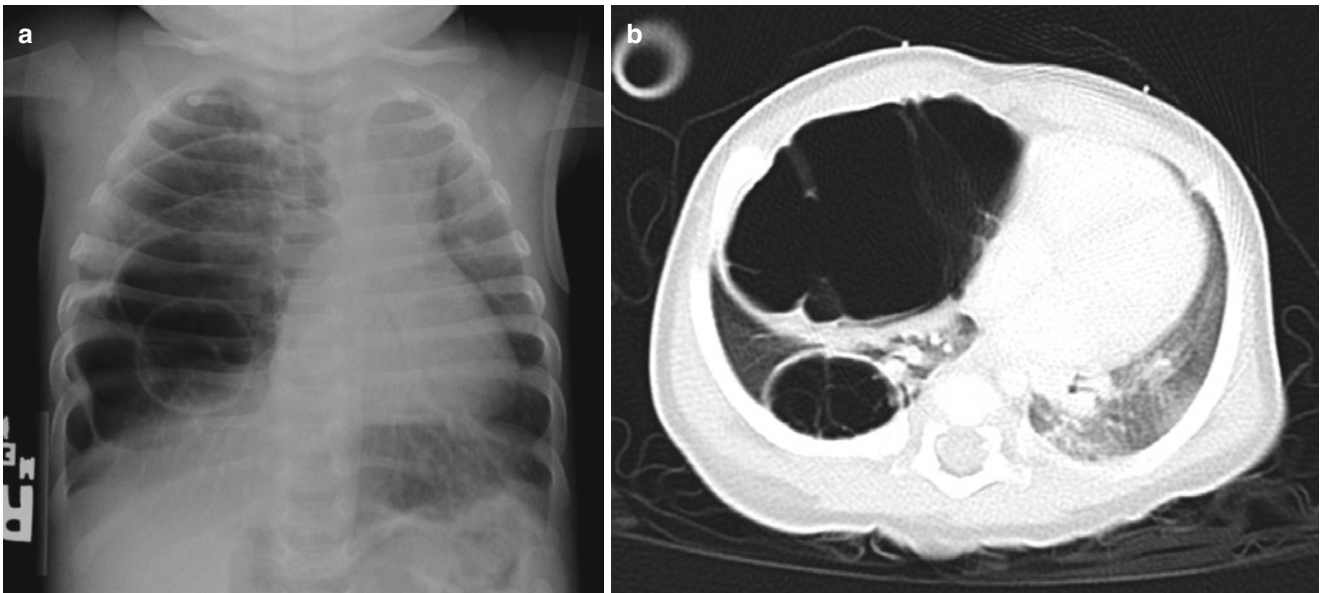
(a) Chest radiograph of an 11 year old female who presented with shortness of breath and a cough demonstrated a right sided pulmonary mass. (b) Her CT scan revealed a multilobular mass and needle
